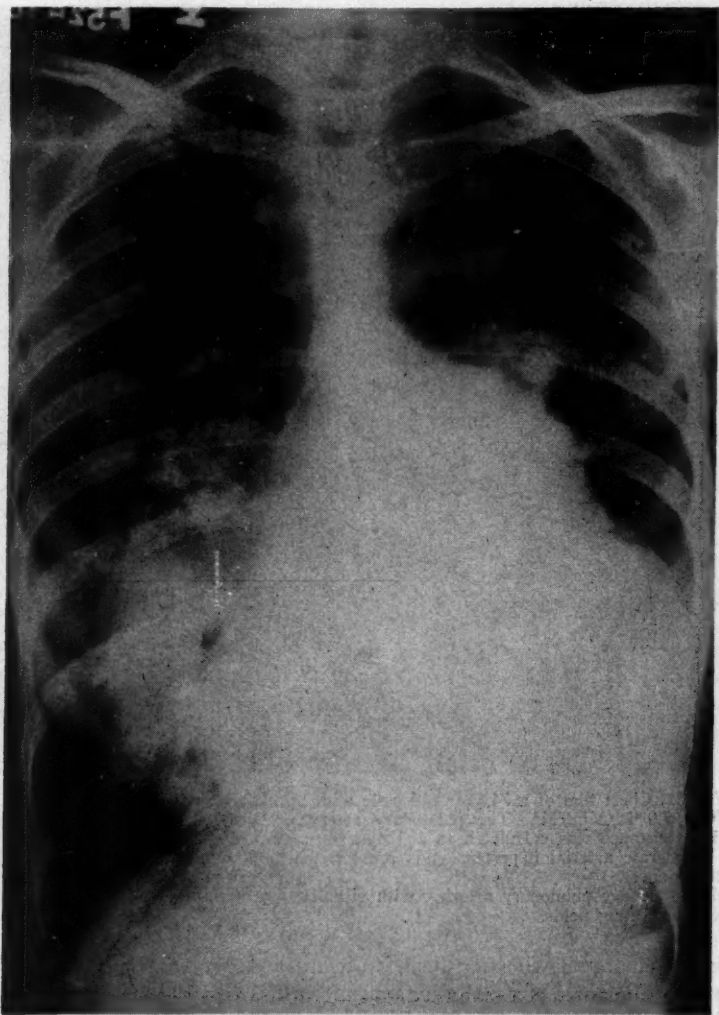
Roentgenogram of 52 year old woman with atrial septal defect. The pulmonary blood flow, 10.6 L./M./M²; pulmonary artery pressure, 88/46; calculated pulmonary resistance, 160 dynes/sec./cm.²/M². Arterial oxygen saturation was 92%.
